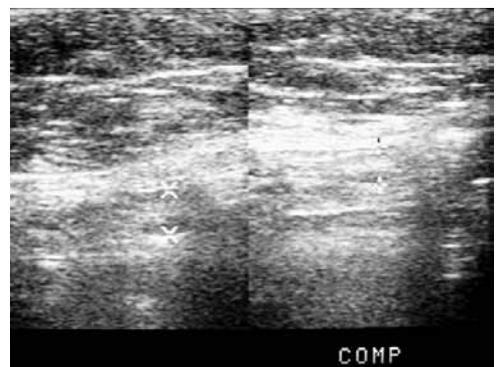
Sonographic axial images of the right lower quadrant in a pregnant patient with pain in this region during her first trimester. The images were obtained without (left) and with (right) compression applied using a linear ultrasound transducer. The appendix is mildly dilated and does not compress, representing acute appendicitis, which was subsequently proven at surgery. Images courtesy of Douglas Katz, MD.
